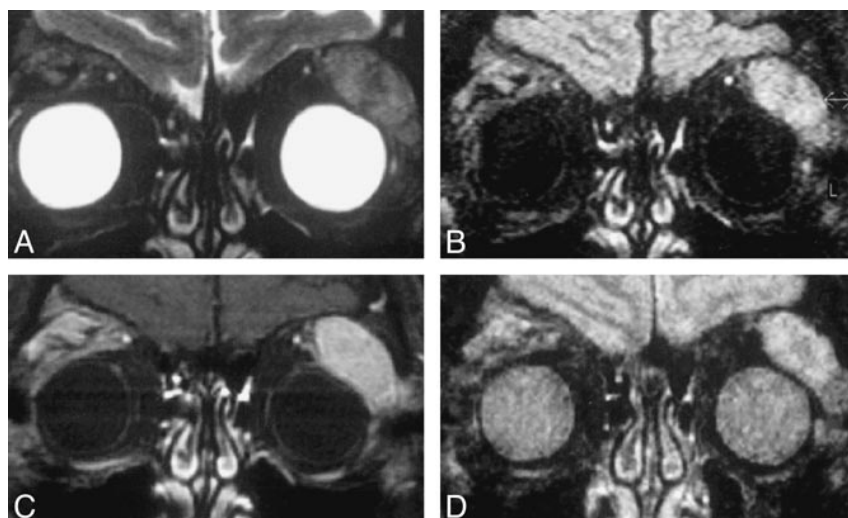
Coronal images through the orbits of a patient with lymphoma of the lacrimal gland. Sequences are T2-weighted SPIR (A), SPIR/FLAIR (B), T1-weighted SPIR with contrast (C), and STIR (D).
